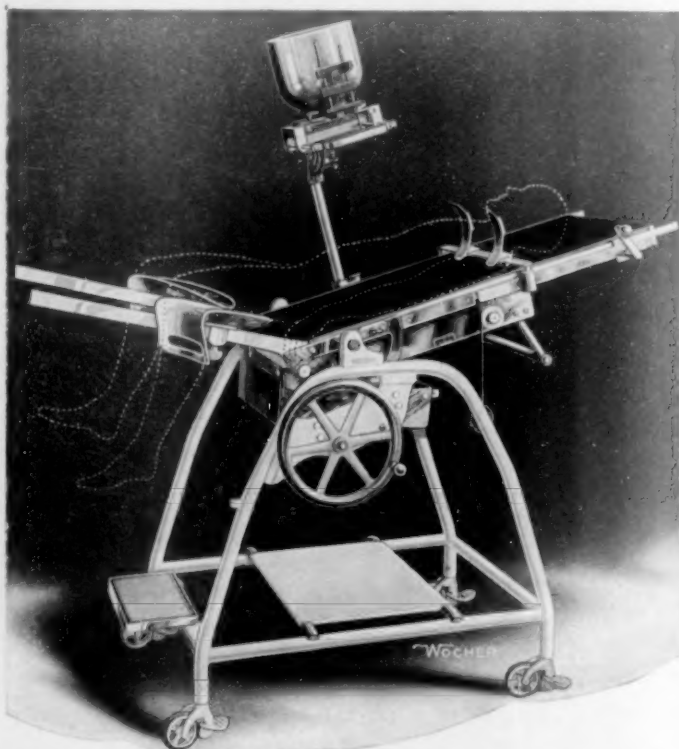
Young's combined cystoscopic and X-ray examining table with new, specially designed flat Buckey diaphragm and the tube stand fixed, with tube in focus on diaphragm. This is the same table as the operating table to which the X-ray equipment is simply added. Table in position for pyelograms to show extreme upward limit of movable kidneys. This position may also be used to fill the bladder with air by negative pressure—Kelly cystoscope.
